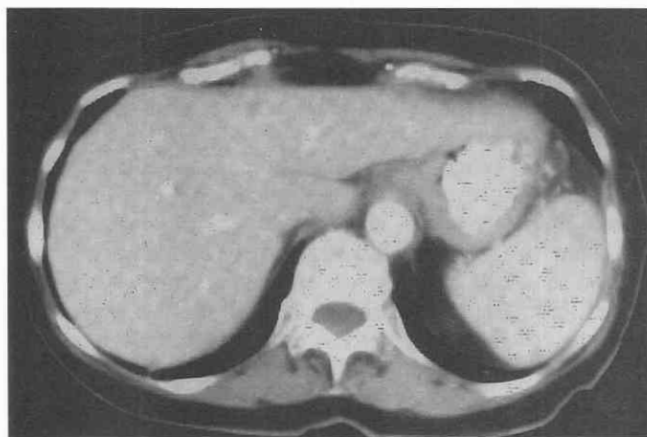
Enhanced CT scan demonstrates multiple low-attenuation candidal microabscesses in this patient with chronic lymphocytic leukemia. A hepatic fungal microabscess is present as well.
